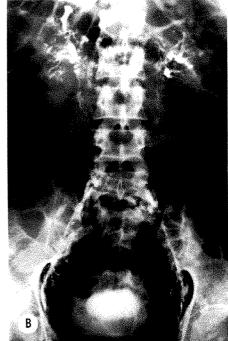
Case vi. Roentgenograms of a 48 year old female with a history of chyluria lasting 2 years. She has been treated with renal and pelvic lavage with 1 per cent silver nitrate. (A) Intravenous urogram showing some fullness of the renal pelvis but essentially normal minor calyces. (B) Roentgenogram taken 24 hours following a lymphogram outlining the fine lymphatic vessels which surround the minor calyces.
